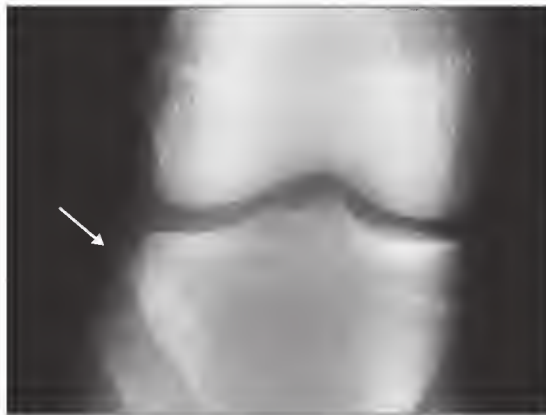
Anteroposterior radiograph of a Second fracture. The figure shows a flake of bone (arrow) and avulsion of the anterolateral capsule in the region of the Gerdy tubercle, frequently associated with rupture of the anterior cruciate ligament.
